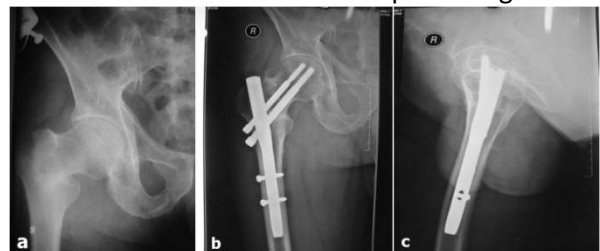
Radiograph of pelvis anteroposterior view (a) showing intertrochanteric fracture, immediate post operative radiograph (b) showing iatrogenic fracture shaft of femur and follow up radiograph (c) showing union of shaft femur after 10 month of follow up.
